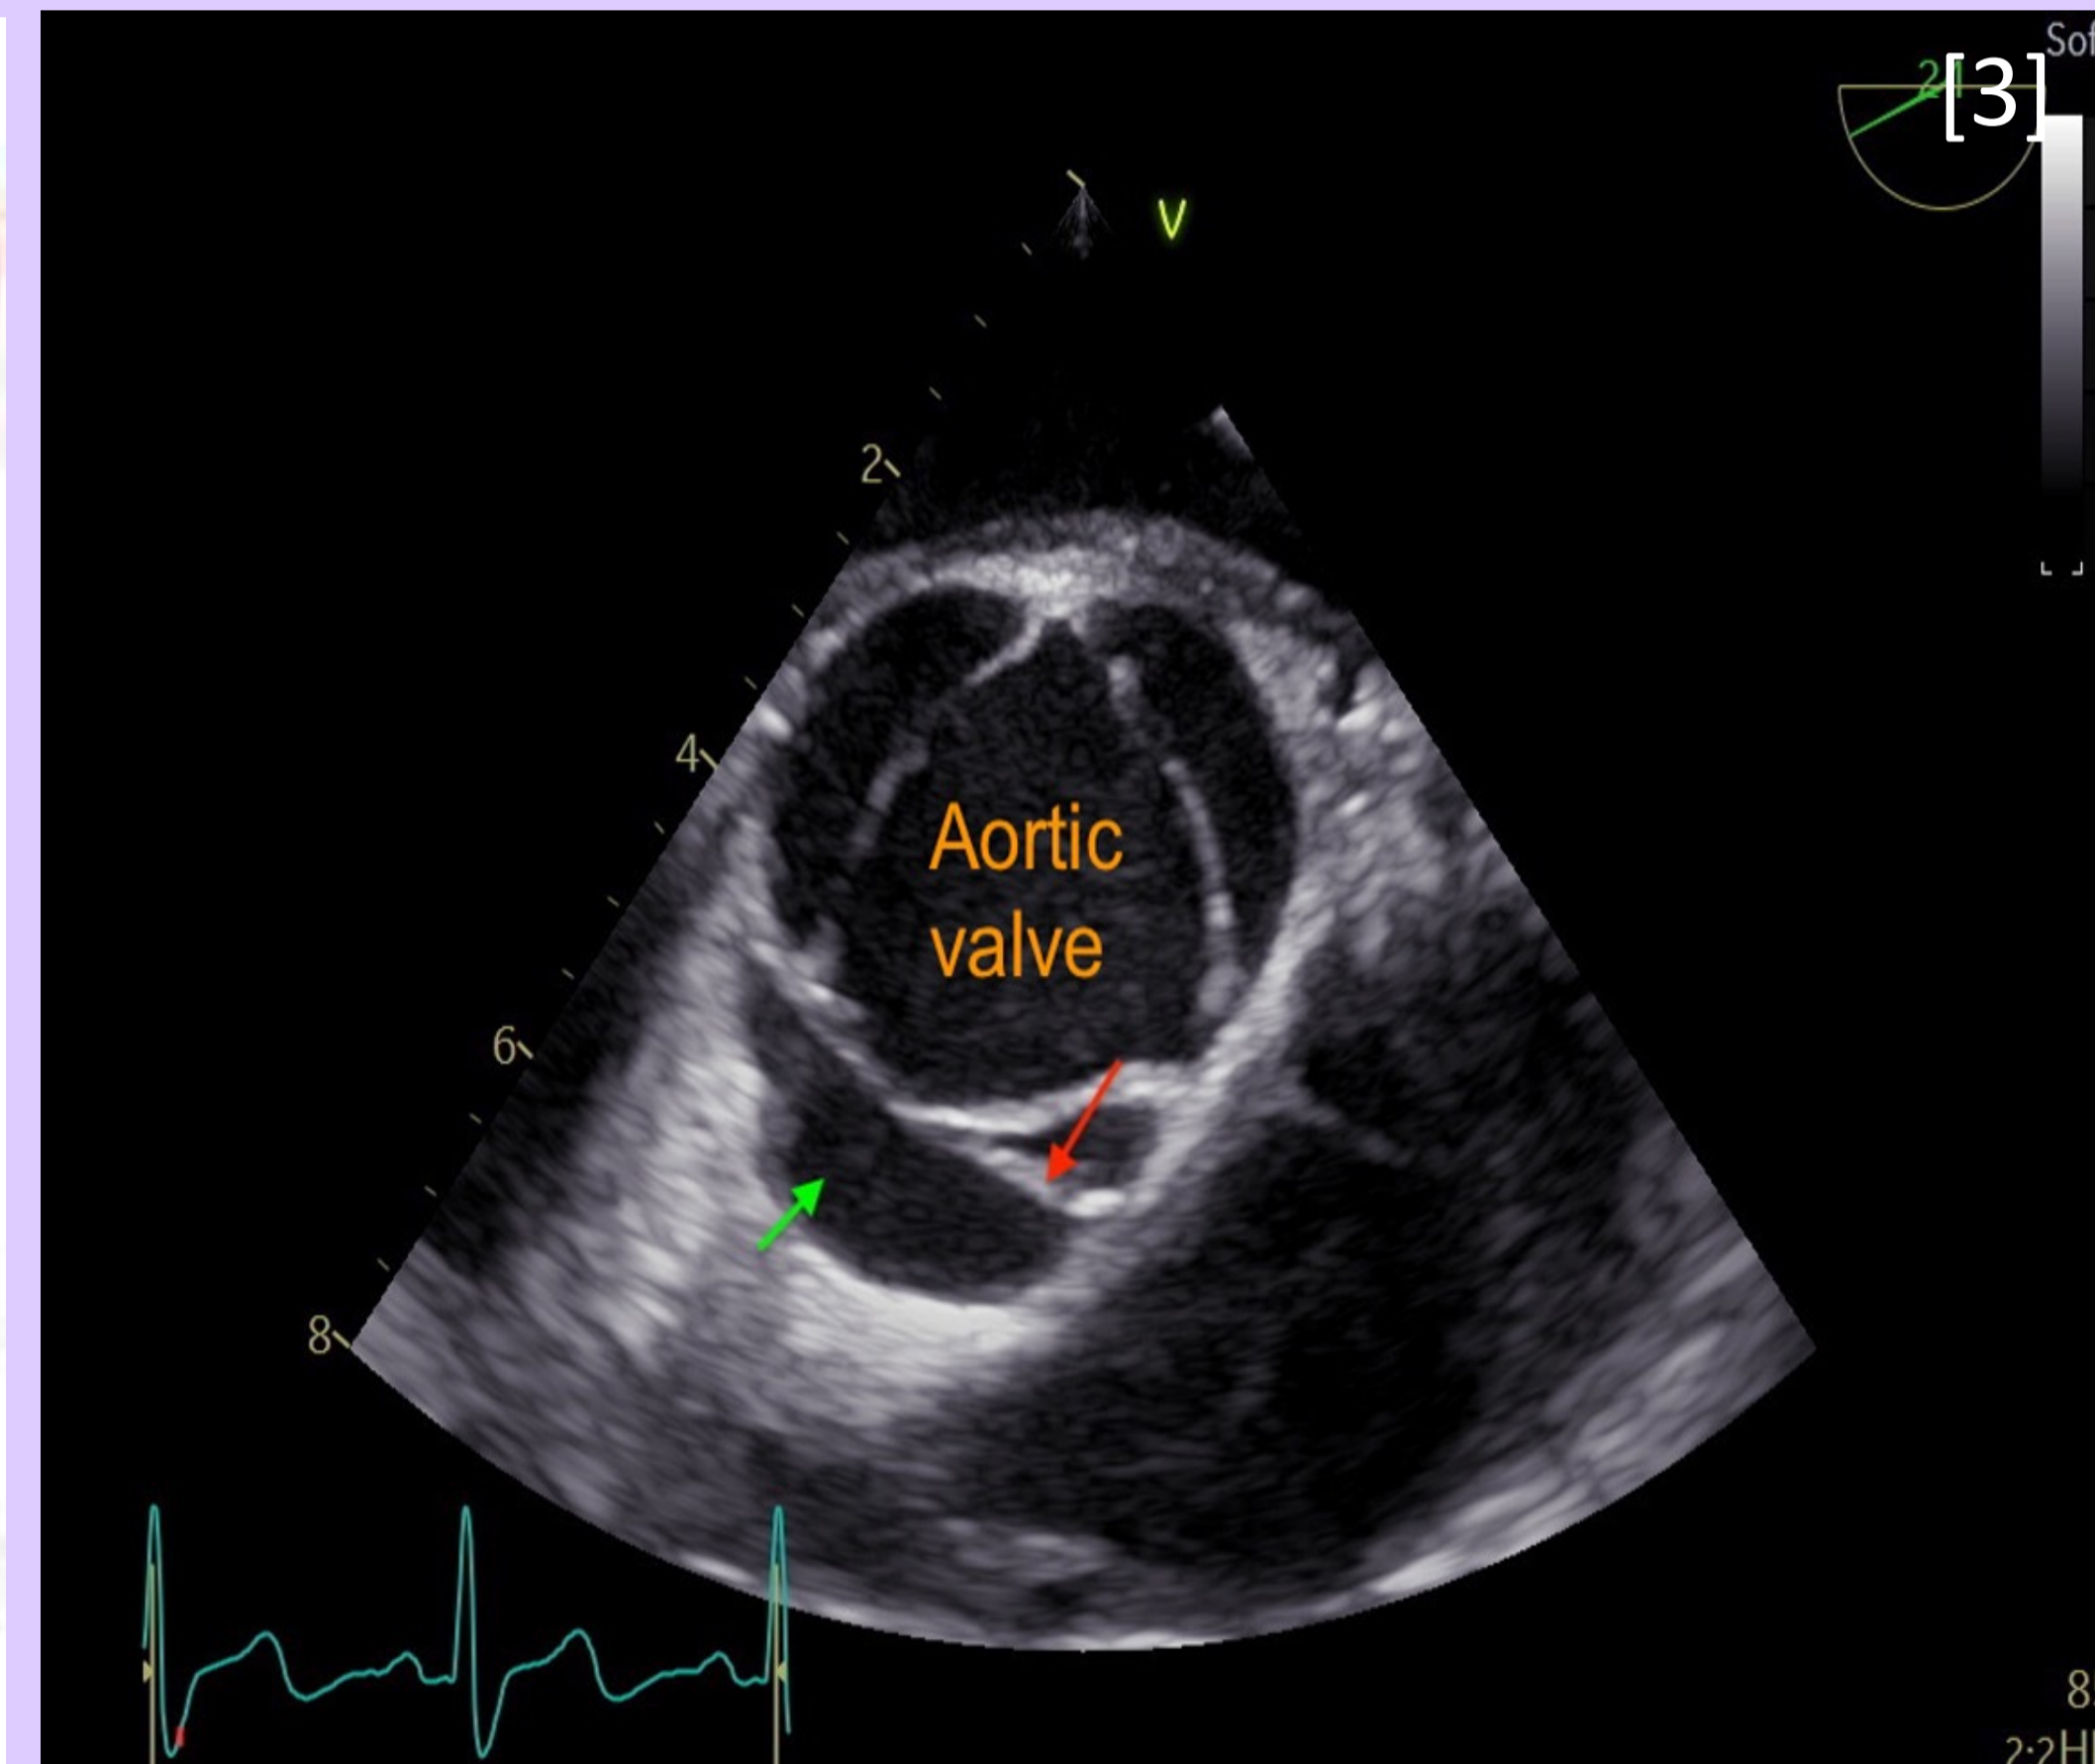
Transesophageal echocardiogram of aortic dissection with visible dissection flap (red arrow) and false lumen (green arrow)
